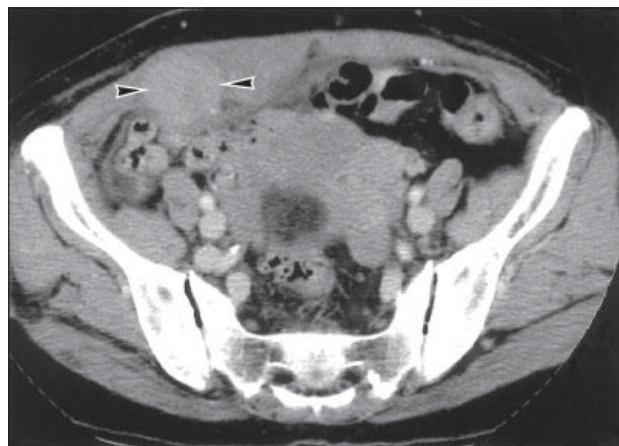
Computed tomography scan of the abdomen shows a haematoma at the level of the right rectus abdominis muscle (arrowheads).
